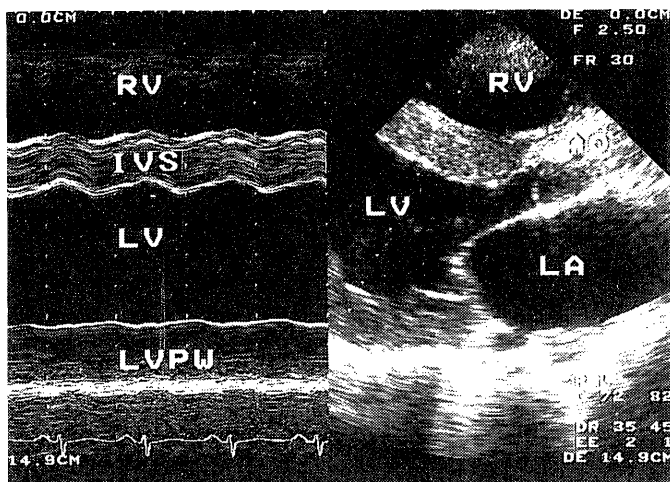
Long axis view of the echocardiography (right figure) and M-mode recording shows akinesis of the left ventricular posterior wall (left figure).
